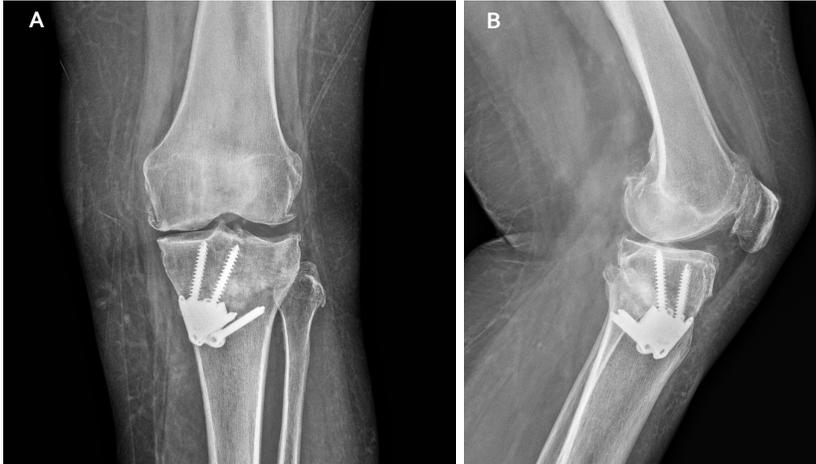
Fluoroscopic or radiographic projections.
